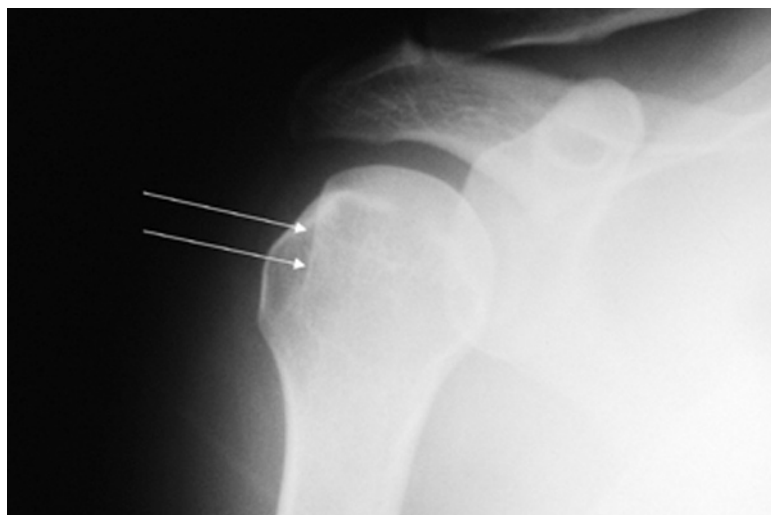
Hill-Sachs lesion. An impaction fracture of the posterolateral humeral head associated with an anterior glenohumeral dislocation is depicted by the small white arrows on this internally rotated anteroposterior radiograph.
